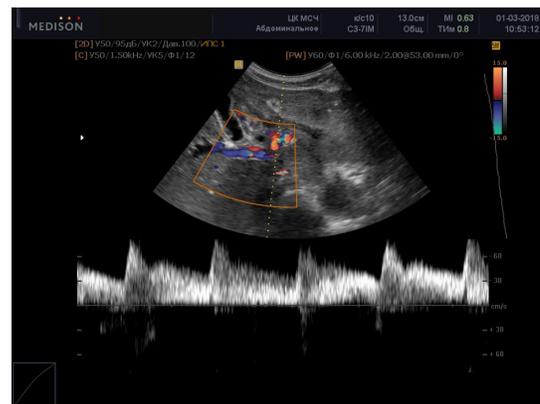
Ultrasound of the SMV in the color duplex scanning mode (06.03.2020)
